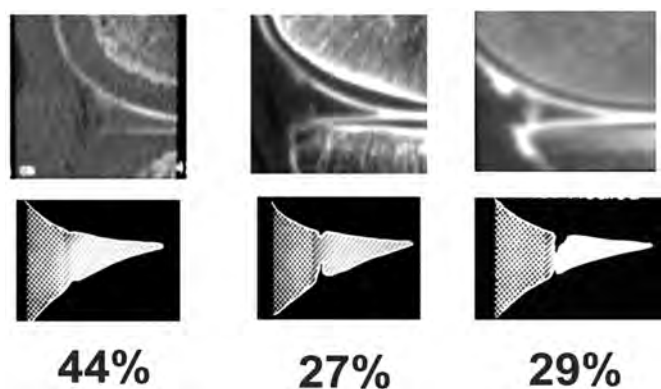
The healing rate in meniscal repair is highly satisfactory when considering CT scan arthrography (courtesy Société Française d'Arthroscopie)
